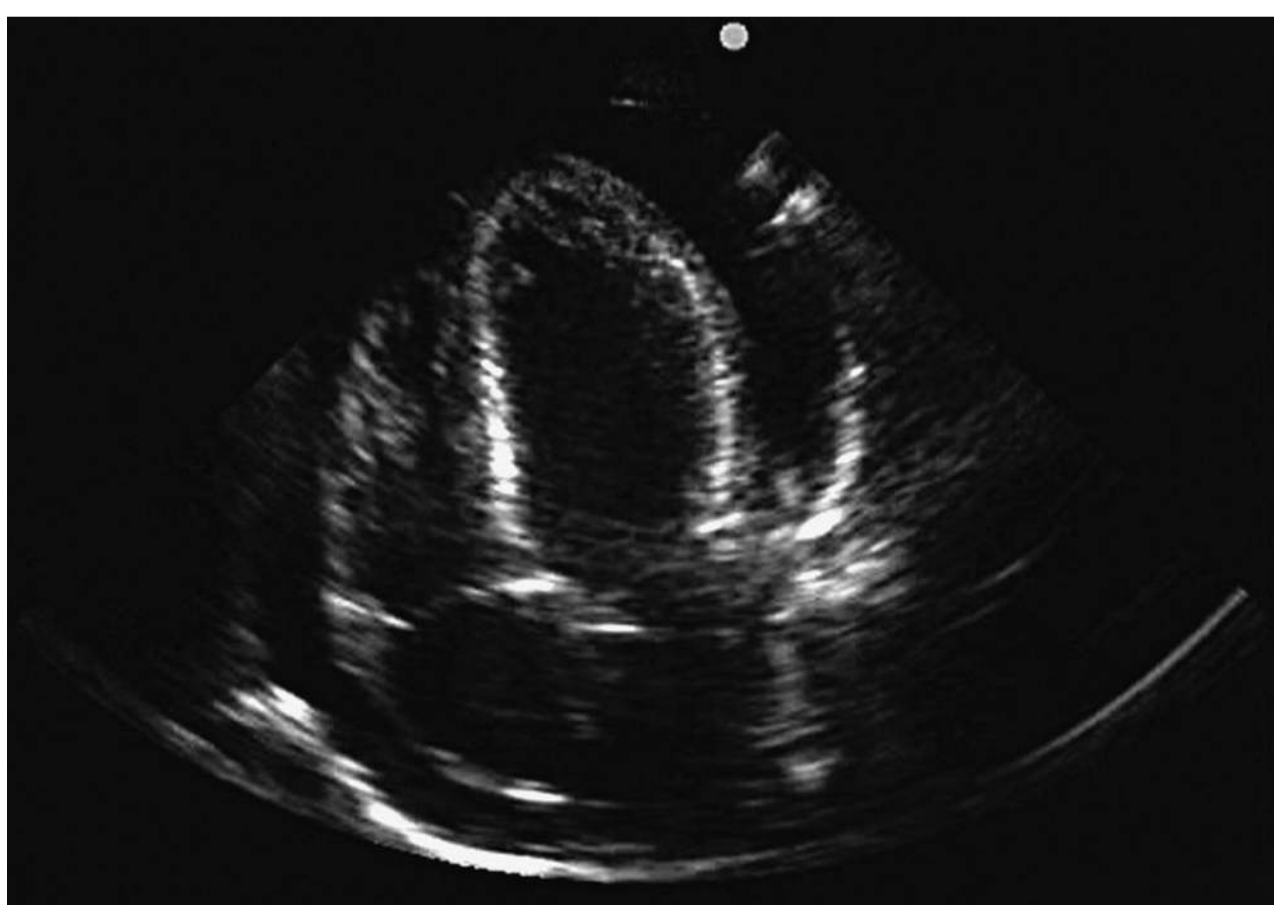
Apical four-chamber view showing a large pericardial effusion with an anechoic fluid stripe circumferentially surrounding the heart. Note the lack of right atrial or right ventricular collapse.
